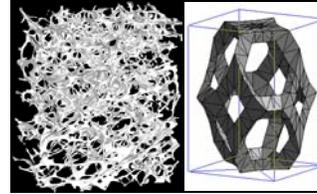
(A) μ CT of trabecular bone structure, (B) and corresponding reconstructed PUC.
